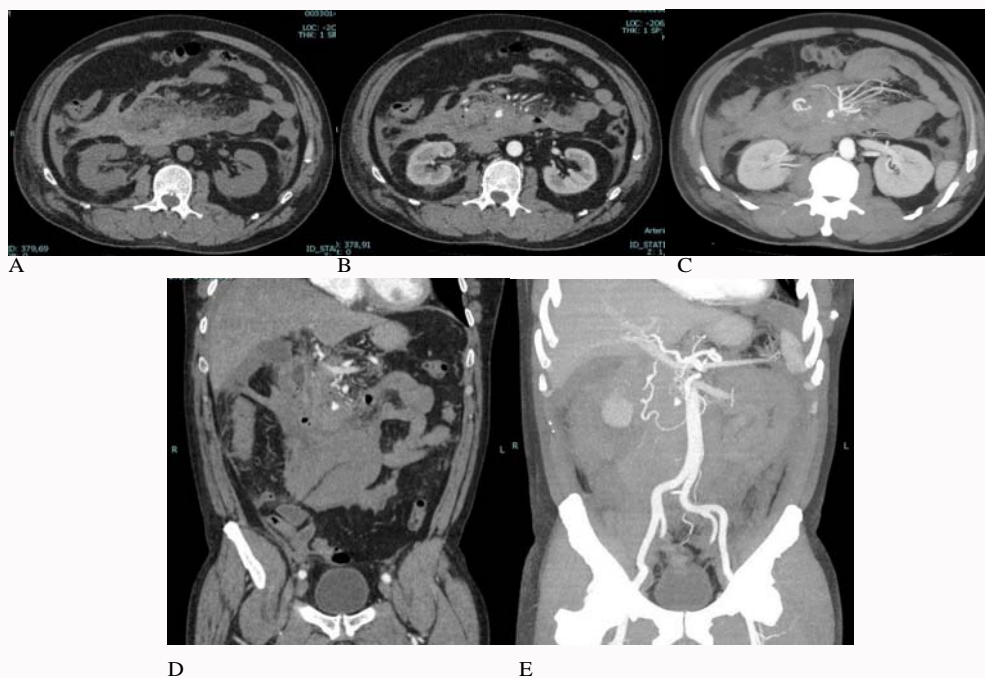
CT examination axial scans. A) baseline examination showing massive retroperitoneal hematoma. B) arterial phase of post-contrast study which shows in the context of the vast hematoma an aneurysm of the pancreaticoduodenal artery. C) MIP reconstruction. D, E) CT examination coronal scans.
